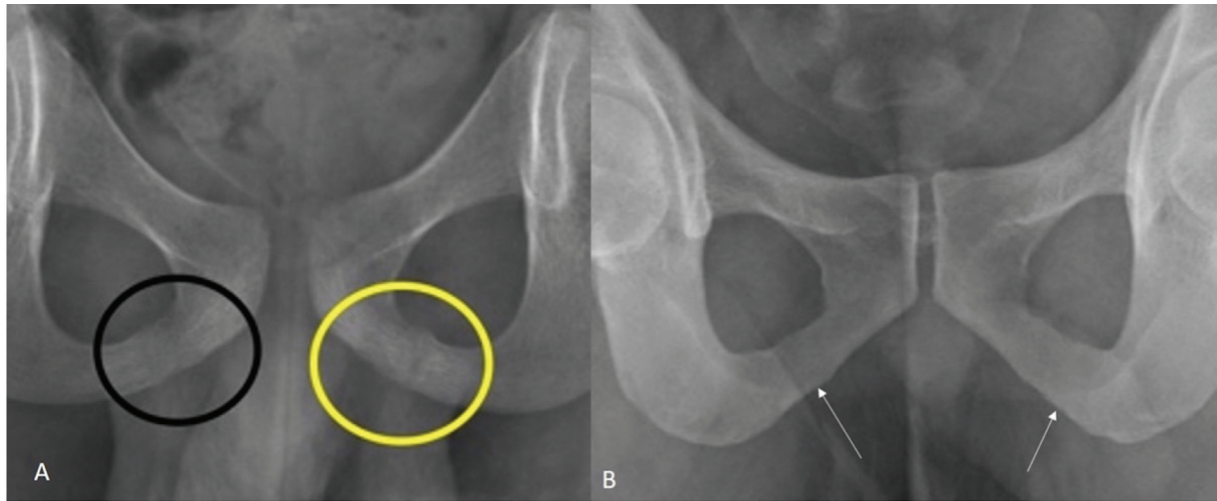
Anteroposterior view of hip joint radiographs showing (A) unfused left ischiopubic joint (yellow circle) and nearly fused right ischiopubic joint (black circle) indicating approximate age of 7 to 8 years and (B) completely fused bilateral ischiopubic joints (white arrows) indicating age above 7 years.
